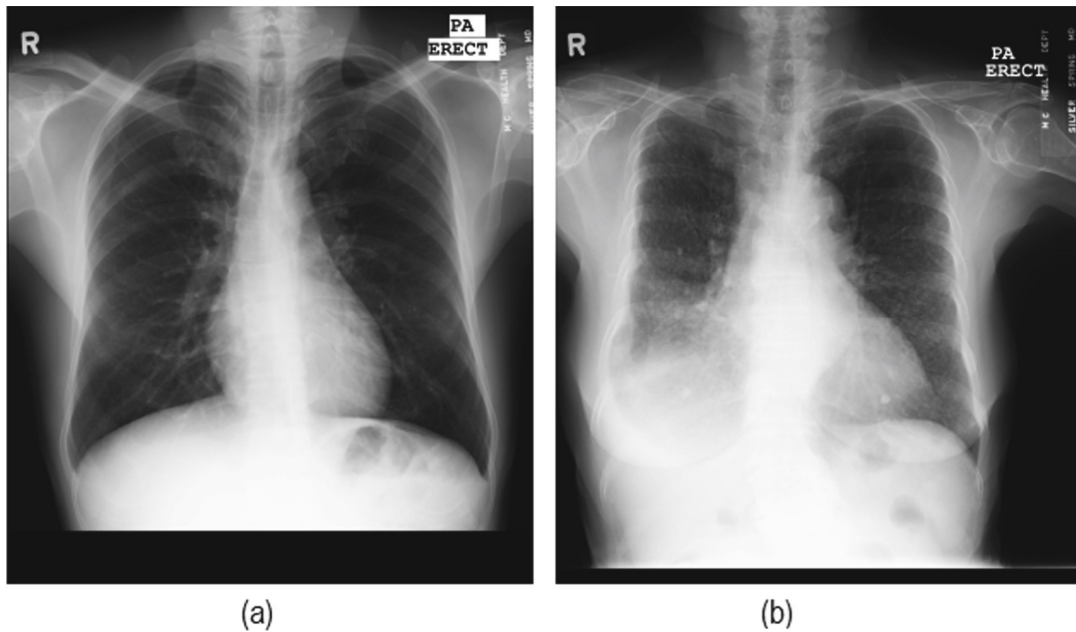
Sample in the Montgomery Database. (a) is a healthy chest radiograph of a 33 years old male patient while (b) is an unhealthy chest radiograph of an 84 years old female patient diagnosed with “bilateral miliary nodules diffusely with right middle lobe and right pleural effusion”.
